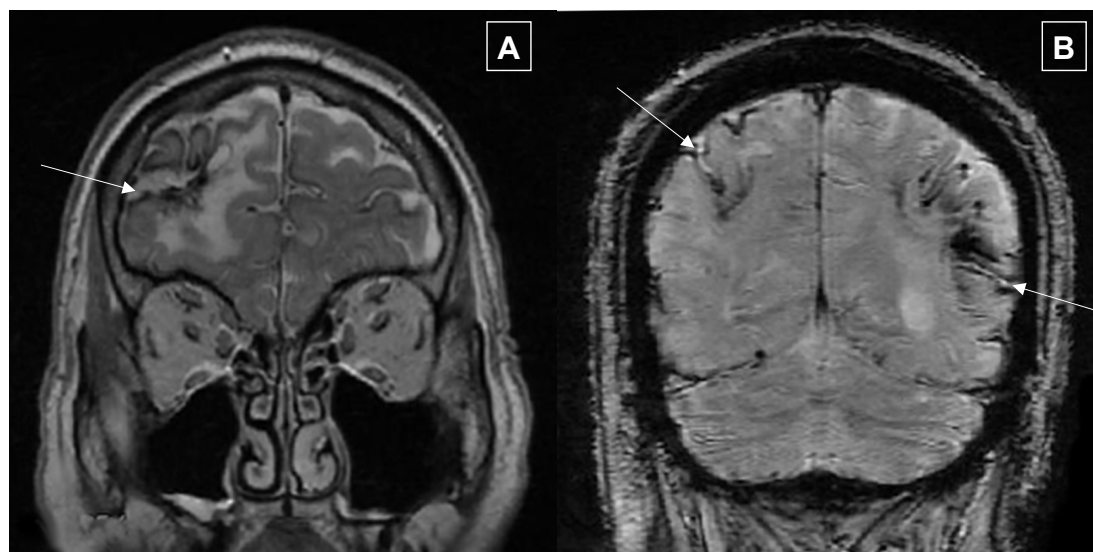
A, B. Coronal T2-weighted GRE sequences reveal areas of focal siderosis (arrows).
